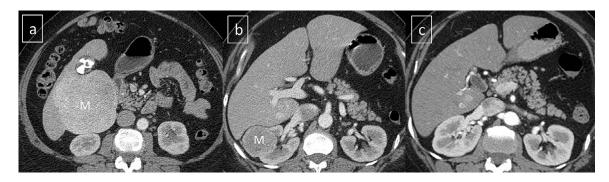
The follow-up portal venous phase computed tomography performed 6 years and 4 months after the initial presentation (patient age 53 years) (a and b); showing significant interval growth of the right hepatic lobe mass (M in a) and a new development of an interpolar partially exophytic right renal mass (M in b). The previous arterial phase computed tomography during the initial presentation at the same level of (b), is provided for comparison (c).
